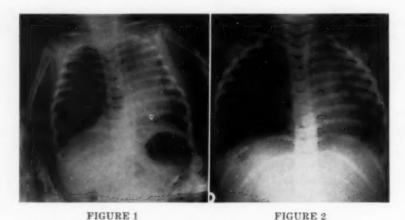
PA roentgenogram on original admission which suggested the diagnosis of right pneumothorax.—Figure 2: Immediately preoperative PA roentgenogram showing increased aeration of right chest with shifted mediastinum and mediastinal herniation of right lung.
